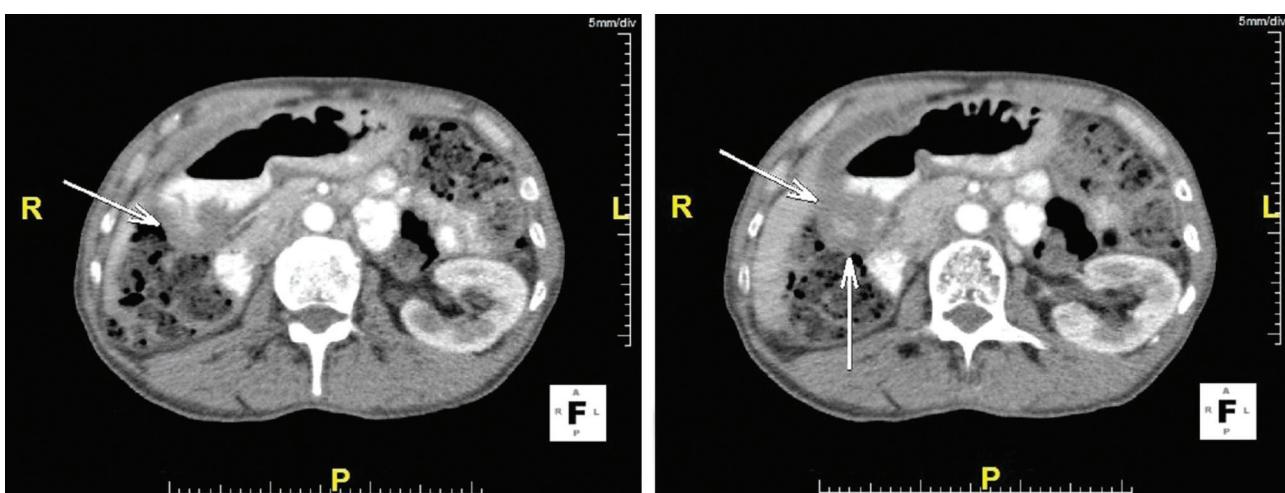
The axial section of the CT demonstrated a circumferentially and concentrically thickened pylorus and proximal duodenal wall up to 18 mm (1 layer) with narrowed lumen and limited contrast passage.
